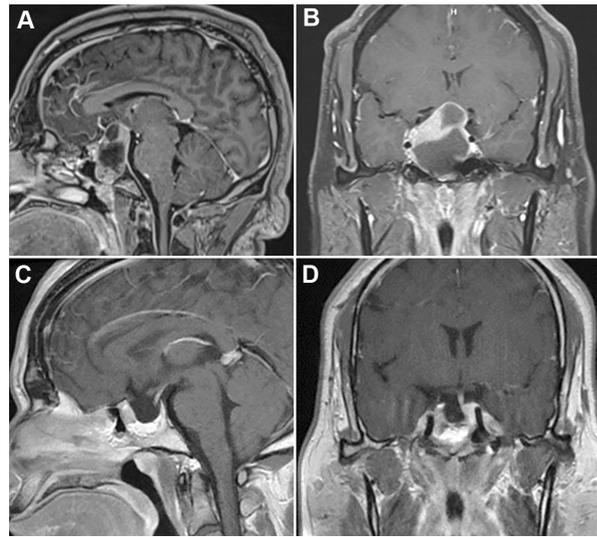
A man in his late 20s experienced a sudden onset of severe headache and blurred vision. Combined trans-sphenoidal approach for giant prolactinoma with intratumoral hemorrhage was performed. Preoperative (A) T1 sagittal and (B) T1 coronal post-contrast MRI of the head shows large intra, para, and suprasellar tumor with intratumoral hemorrhage with compression of optic chiasm and infiltration of cavernous sinus. Postoperative (C) sagittal and (D) coronal post-contrast T1 MRI of the head shows complete resection of the tumor and intact pituitary gland/stalk. Visual symptoms recovered and prolactin serum level improved significantly (preoperative, 1000 nmol/L vs. postoperative, 200 nmol/L) following surgery.
